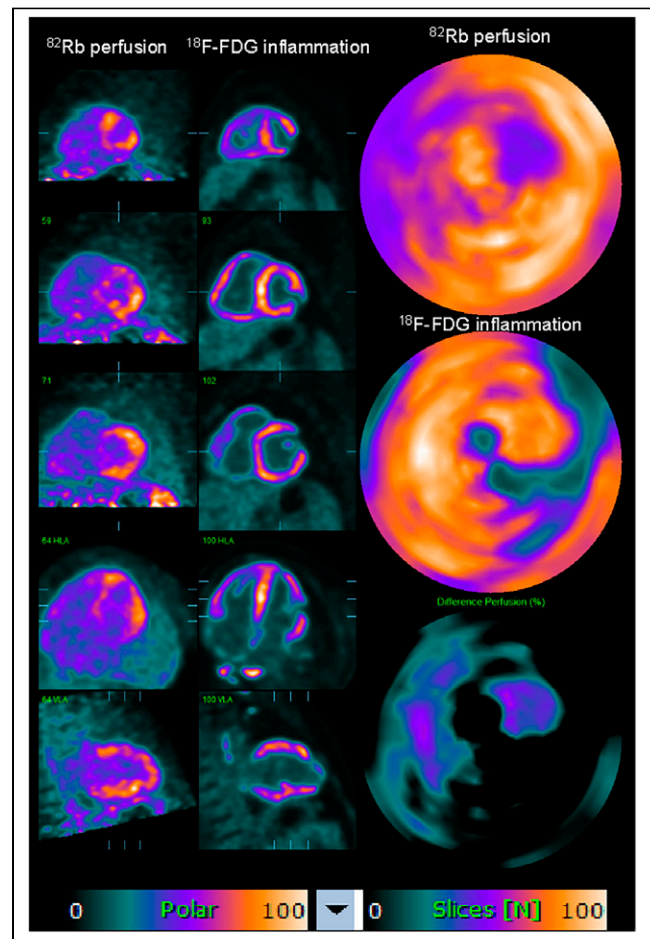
Column with resting ^{82}Rb perfusion images shows patchy perfusion in septum and in part of anterior and apical anterolateral walls. Column with ^{18}F -FDG images shows active inflammation in septum, anterior wall, and apical anterolateral wall indicative of perfusion and metabolism mismatch. Additional active inflammation demonstrated in right ventricle and papillary muscles is suggestive of biventricular involvement. Polar plots show mismatch between areas of perfusion and inflammation defects.
